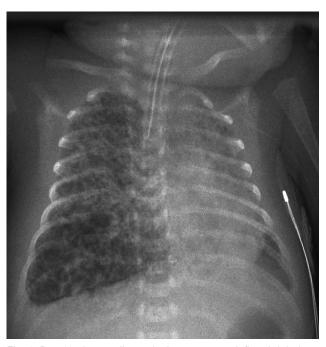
Day 13 chest radiograph shows an over-inflated right lung with severe localized pulmonary interstitial emphysema, and an under-inflated left lung.
